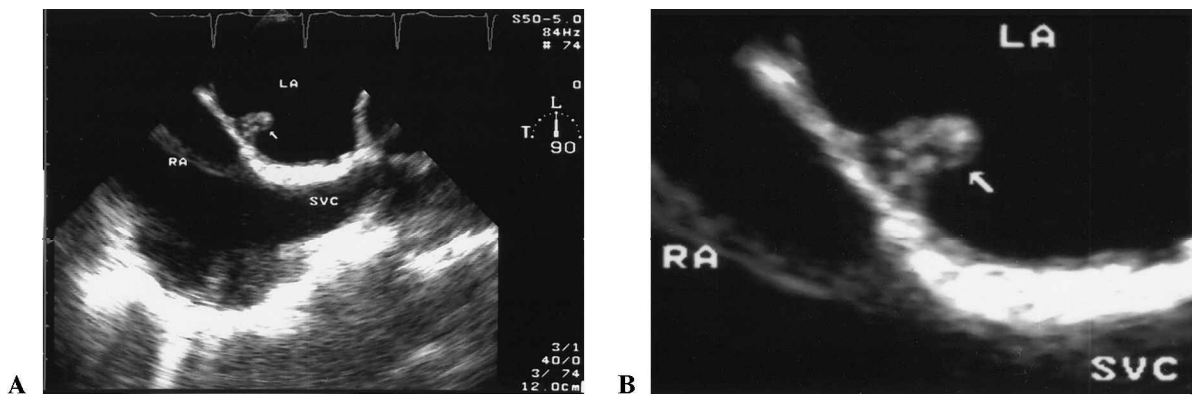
A. TEE image in the vertical plane again demonstrates the mass attached to the mid-portion of the left atrial side of the fossa ovalis. B. Close-up image again suggests a heterogeneous appearance of the mass. TEE = transesophageal echocardiography.
